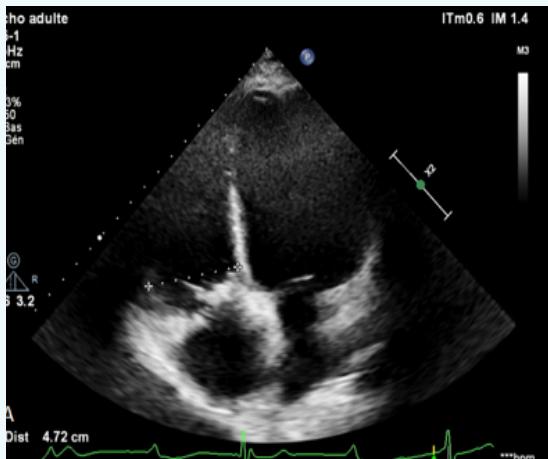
2D echocardiography in the apical 4 chambers view showing dilated right cavities.
